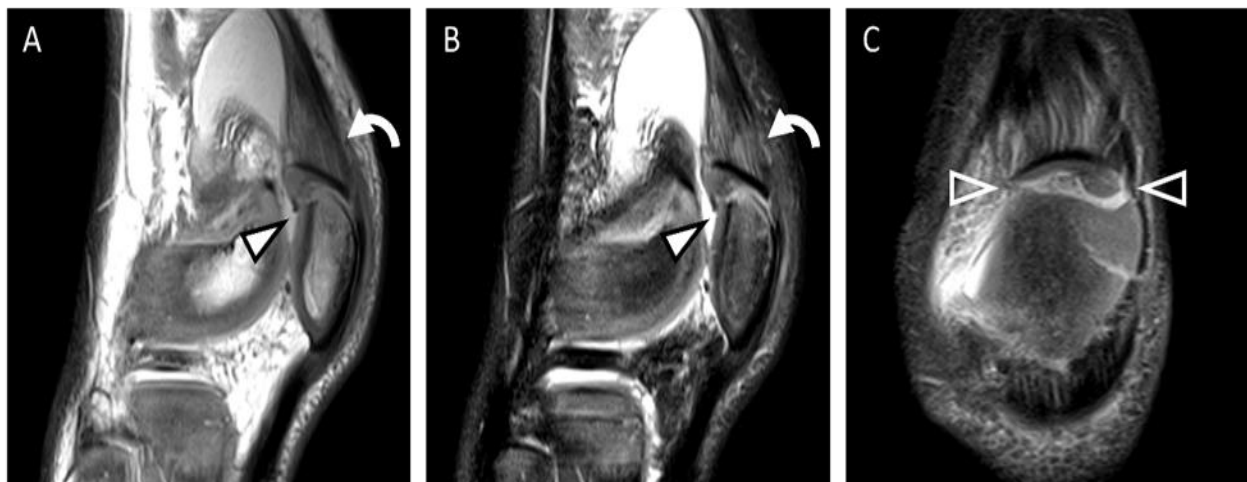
Unenhanced MRI of the left knee. (A-B) Sagittal PD (A) and T2 fat-suppressed (B) MR images reveal an osteochondral fracture involving the periosteum and non-ossified superior patellar cartilage (solid arrowheads). The distal quadriceps tendon (curved arrows) attaches to the displaced fragment and is intact. (C) Coronal PD fat-suppressed MR image demonstrates a 2.5 mm osteochondral fracture cleft through the superior pole of the patella (open arrowheads).
